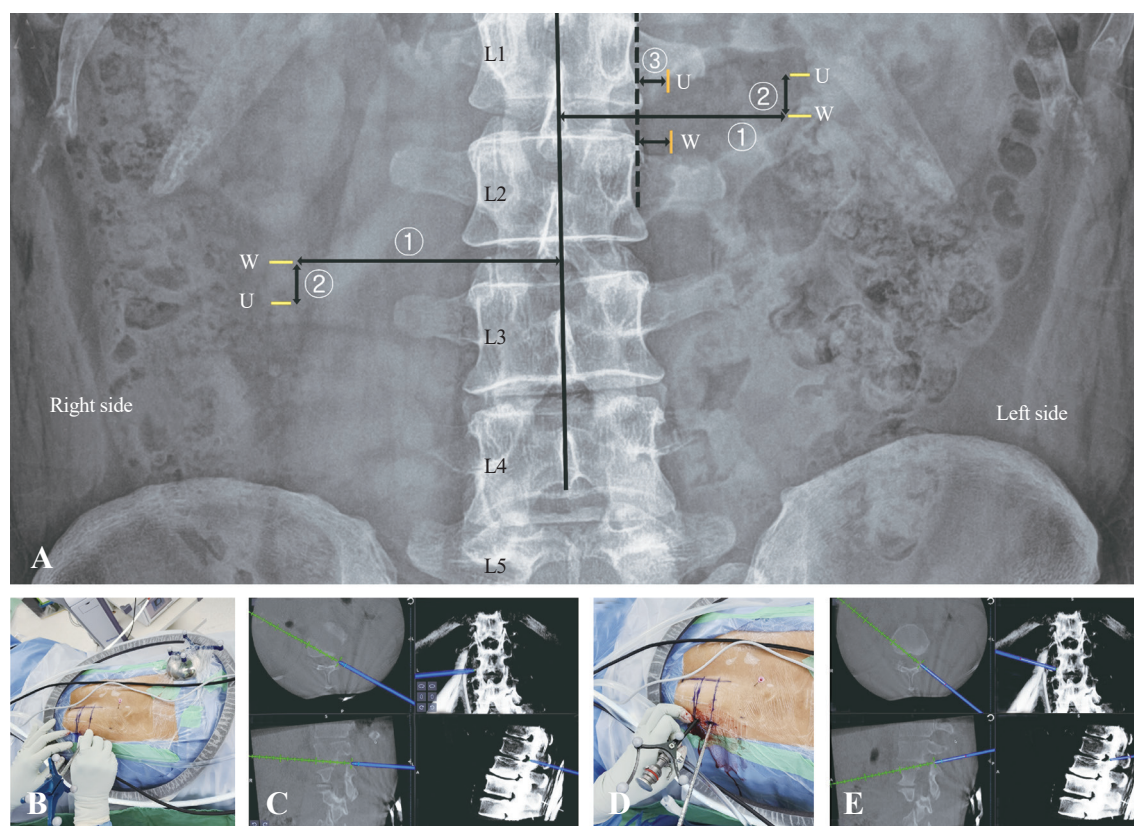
(A) W denotes the working portal, whereas U denotes the unilateral biportal endoscopy (UBE) portal. Orange vertical lines: the placement of portals in the paraspinous approach. Yellow horizontal lines: the placement of portals in the transforaminal-UBE. Dashed line: the lateral margin of the pedicle line. 1, 2, and 3: distances to portals, where 1 is 7.0–11 cm, 2 is 2.5–4.5 cm, and 3 is 2.0 cm. The working portal in the transforaminal UBE is made parallel to the target disc level. The endoscopic portal is made approximately 2.5–4.5 cm cranial or caudal to the working portal. (B) Insertion of the navigation dilator probe into the working portal incision. (C) During probe insertion, intraoperative computed tomography (CT) navigation was used to accurately identify the anatomic location. (D) Insertion of the UBE trocar with SureTrak II Universal Tracker (Medtronic Inc., USA) into the UBE portal incision. (E) During UBE trocar insertion, intraoperative CT navigation was used to accurately identify the anatomic location.
